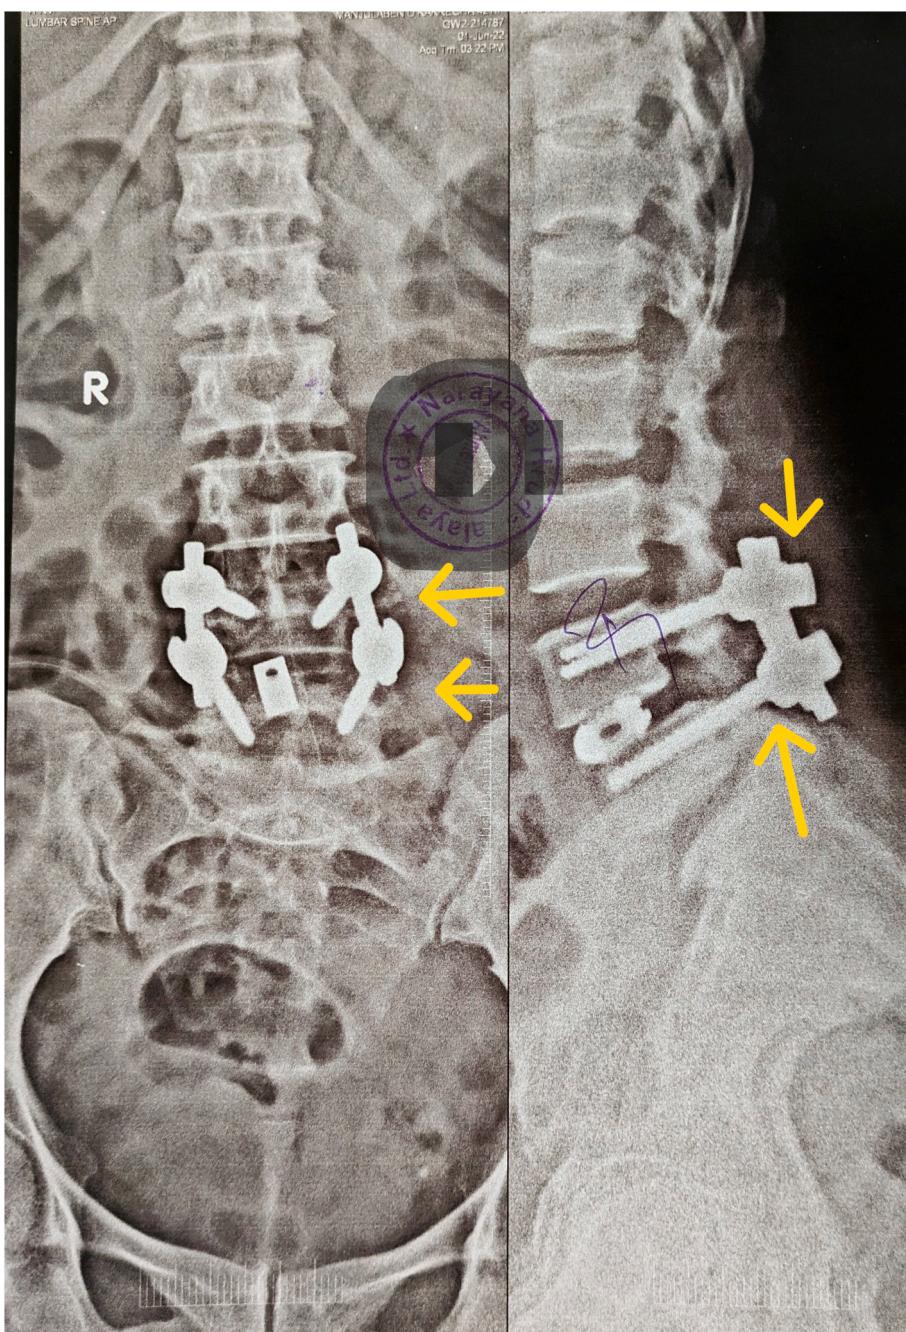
Postoperative lumbar spine x-ray: status post L4-L5 TLIF, Decompression, and posterior fixation.
